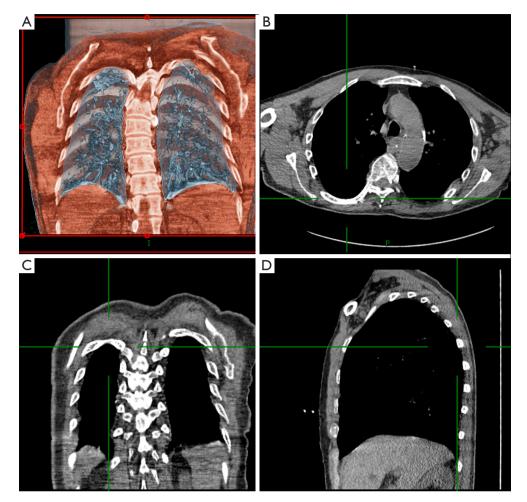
Lung CT plain scans and three-dimensional reconstruction after lung recruitment therapy showing the inflated part of the lungs and significantly reduced consolidation of the dorsal side compared to the previous scan. (A) Chest CT three-dimensional reconstruction (abdomen and lung structure rendering) in the coronal plane; (B) chest CT in the horizontal plane; (C) chest CT in the coronal plane; (D) chest CT in the sagittal plane.
